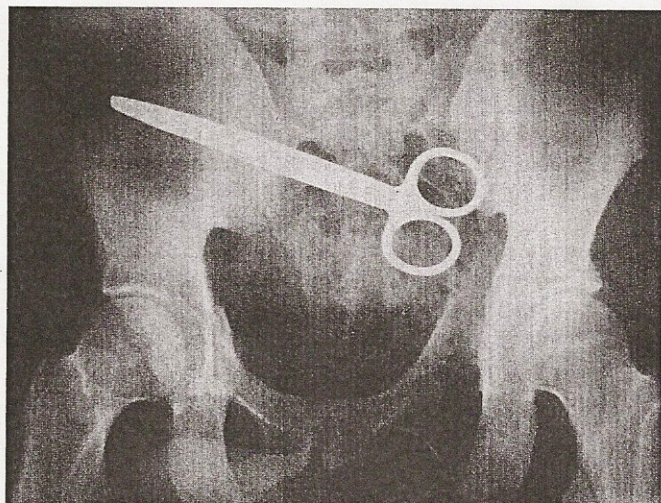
Subsequent anteroposterior radiograph demonstrating satisfactory reduction after circumferential antishock sheet application (while traction was applied to the right leg).
